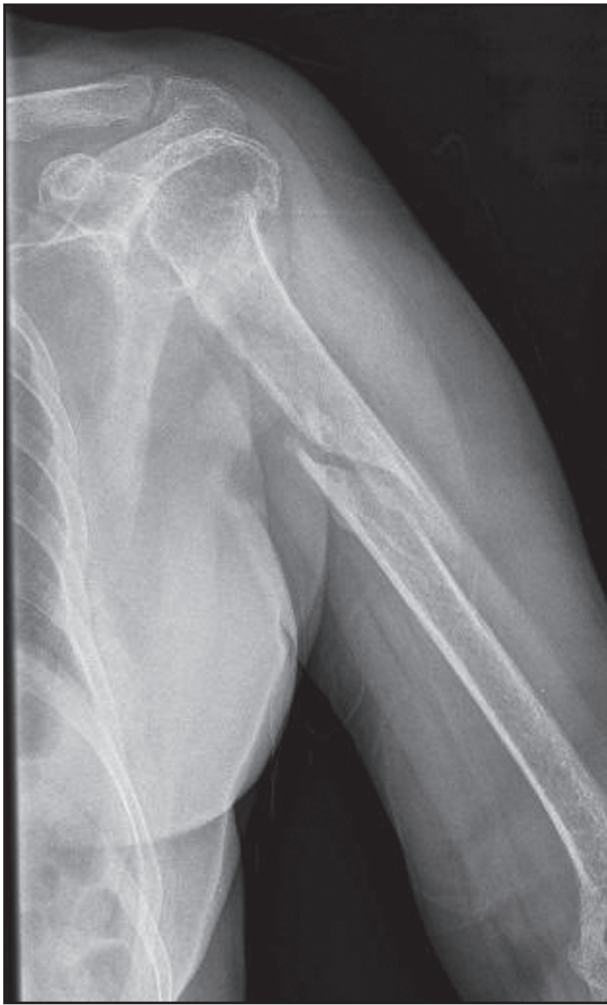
Anterior-posterior radiograph with humeral internal rotation exposing the lateral aspect of the left humeral midshaft. Complete displacement can be seen.
